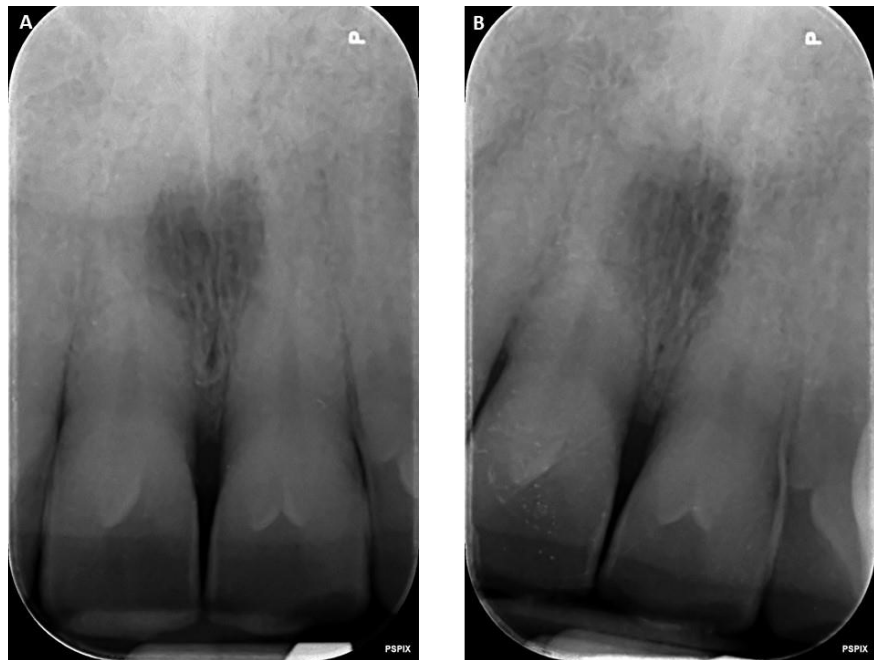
A- Digital x-Ray after 2 months. B- Digital x-ray after 4 months shows a bone defect reduction and an increase of mineralization.
